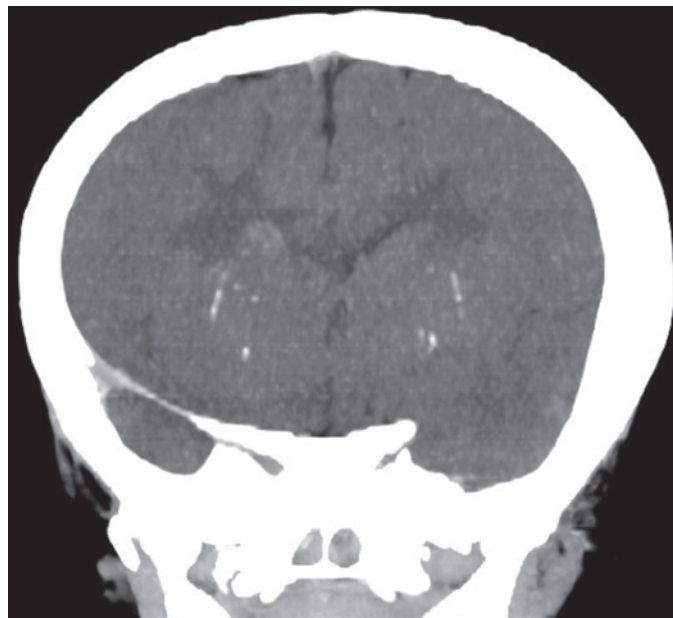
Coronal CT scan - Punctate micro calcifications in bilateral basal ganglia, in MALS.
